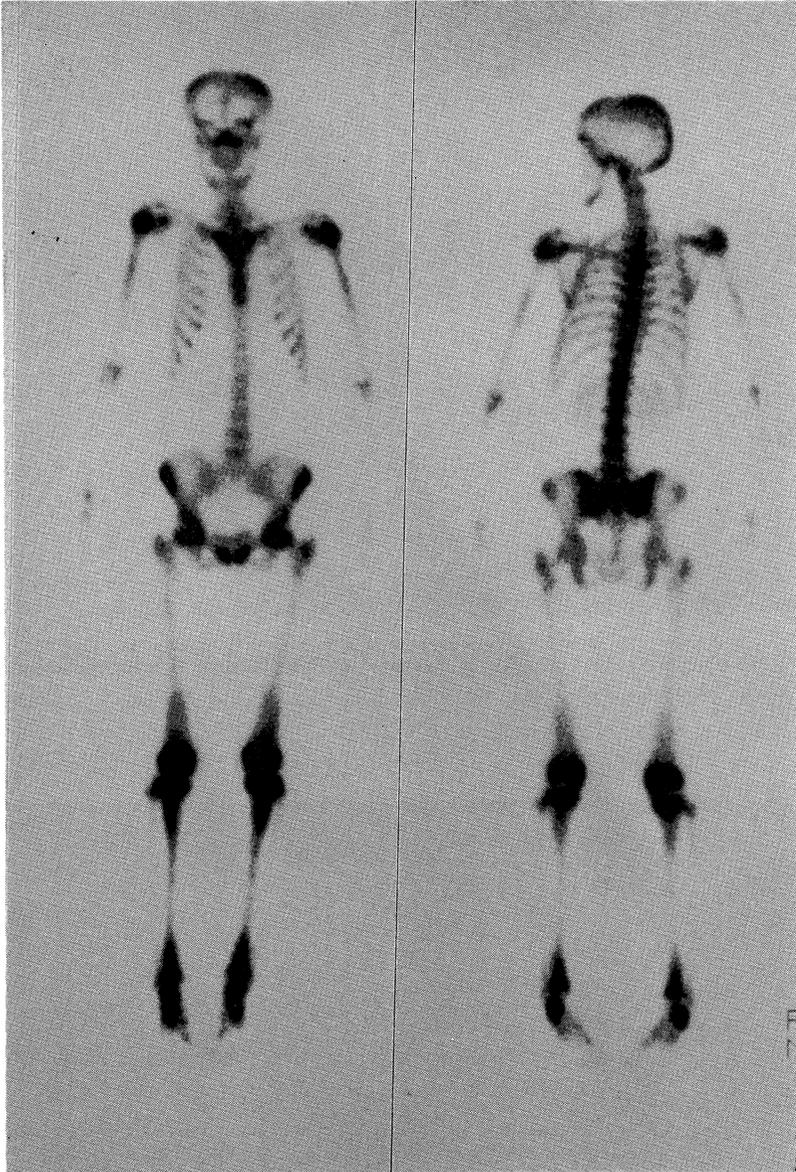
Bone scintigraphy shows diffusely increased skeletal uptake, especially in distal femur and proximal tibia.
